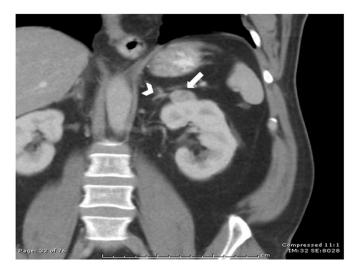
Coronal contrast-enhanced CT image. Heterogeneous mass projecting exophytically from the upper pole of the left kidney (arrow). The mass appears to be enhancing. The adjacent left adrenal gland (arrowhead).
